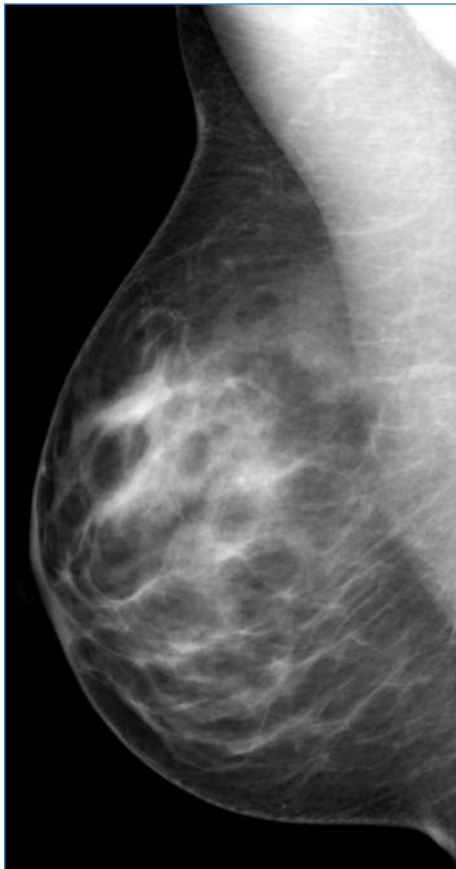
Full Field Digital X-Ray mammogram of the right breast in the "medial-lateral oblique" projection. Normal heterogeneously moderately dense fibroglandular tissue is seen. There are no masses, abnormal microcalcifications, or other obvious signs of breast cancer.
